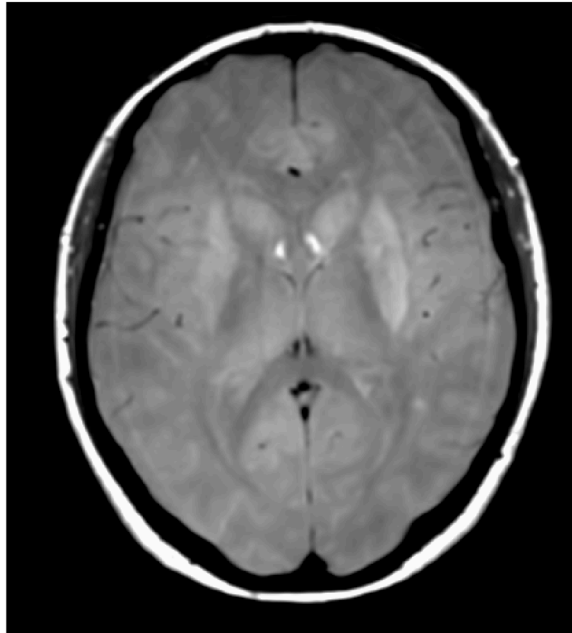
An example of axial Proton Density MRI image of the brain.
